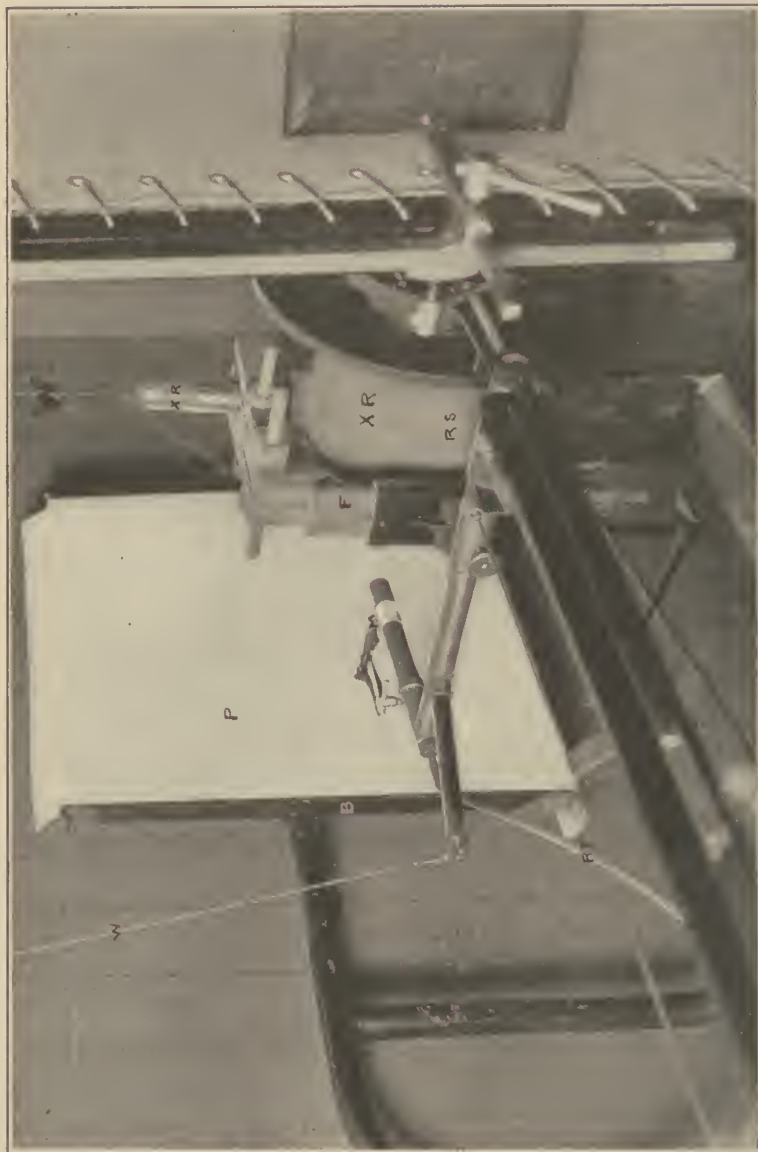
Details of marking mechanism: XR, X-ray tube which may be raised or lowered in its frame (F). It is partially protected by its rubber shield (RS). The marker (M) is in line with the center of the screen (see Fig. 234) and the focus of the X-ray tube. The rubber tubing (RT) is connected with the rubber bulb (Fig. 234) through the hollow cross bar. When the bulb is squeezed and the marker inked, the pencil is pushed forward and dots the paper (P) fastened upon the board (B). W, are the wires connecting the X-ray tube with the coil.
